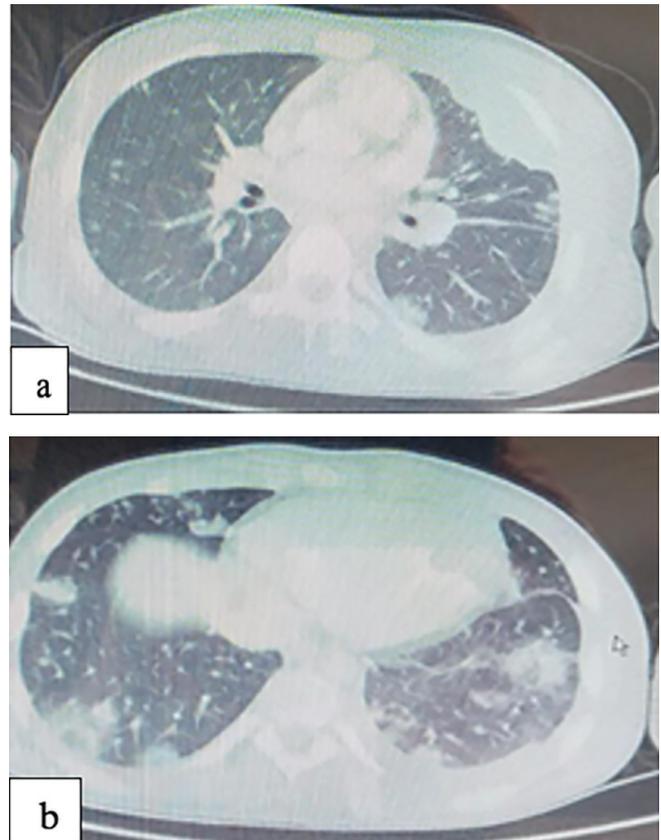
a-b) Thorax CT on 1st day
